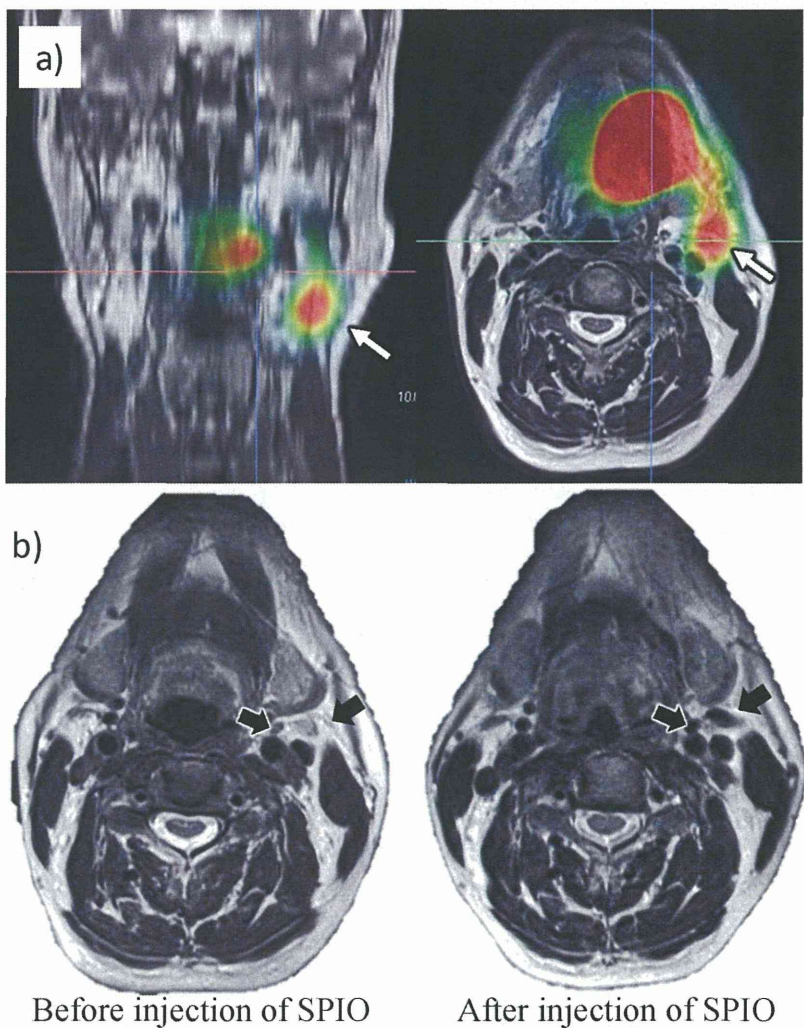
Case2; a) The location of SLNs was identified in the left upper neck by SPECT (open arrows). b) The signal attenuation was shown by MRI (T2W, closed arrows). The area with decreased signal was anatomically coincided with the hot spot in photo a.
